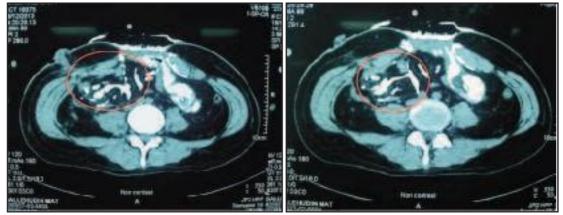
CT Scan Images showing multiple linear branching opacities with trabecular ossifications.
